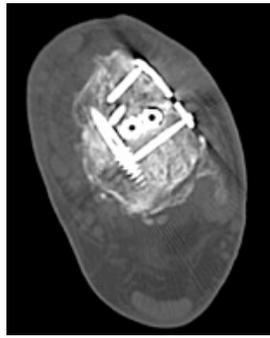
B (Postoperative axial CT scan showing healed talus fracture)
